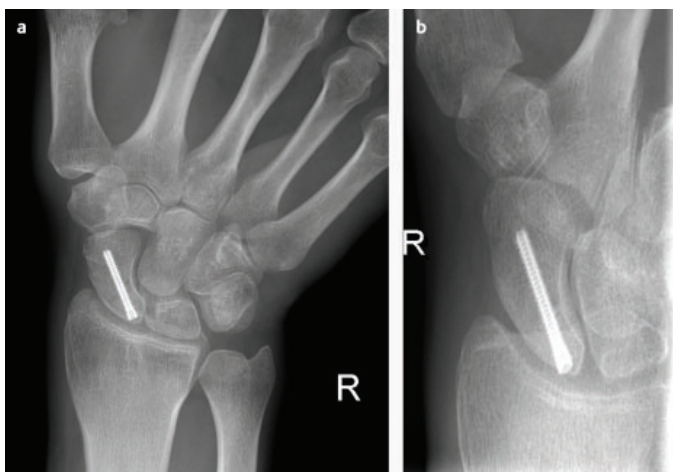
(a) Posteroanterior and (b) Ziter view radiographs, nine months after surgery, showing the scaphoid fracture union with a headless screw in situ
